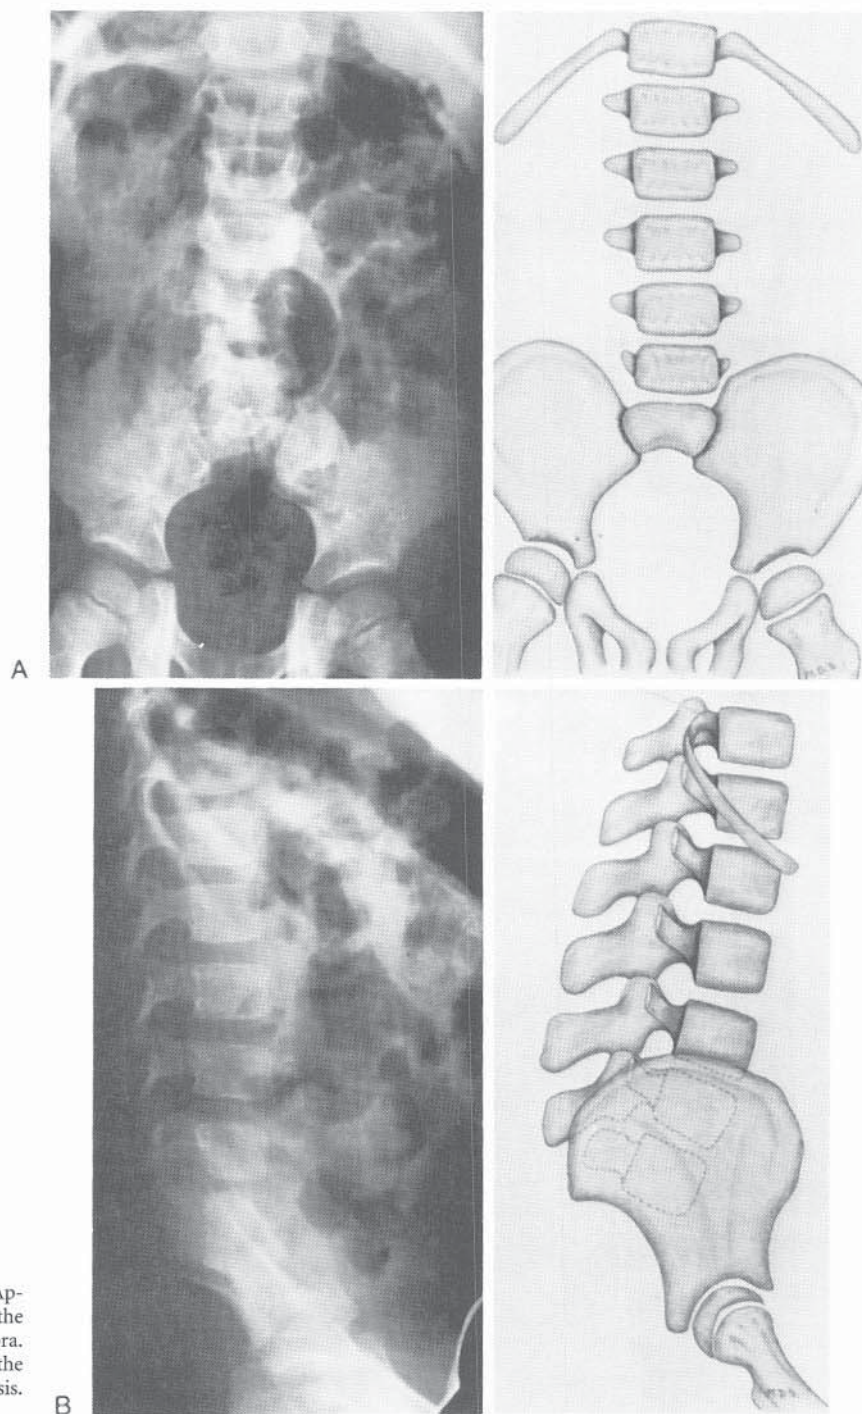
Type II lumbosacral agenesis. A, Appearance on AP radiographs. Note the absence of the lower sacrum and the hypoplastic first sacral vertebra. B, The lumbopelvic articulation is evidently stable on the lateral radiograph. (From Renshaw TS: Sacral agenesis. *J Bone Joint Surg* 1978;60-A:373.)
